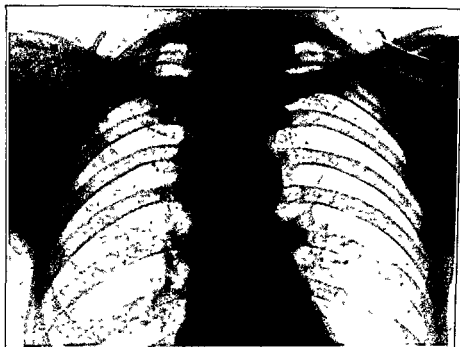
With bacilli found in sputum the only roentgen findings were along paravertebral border above right hilum. The changes are rather limited in extent but definite. Their location is proper for the apex of lower lobe. Stereoscopy shows a posterior position. The "paravertebral" form is placed in a special classification from "subclavicular," etc. Patchy infiltrations must be present; not merely exaggerated trunk markings, to justify the inference of significant disease.
